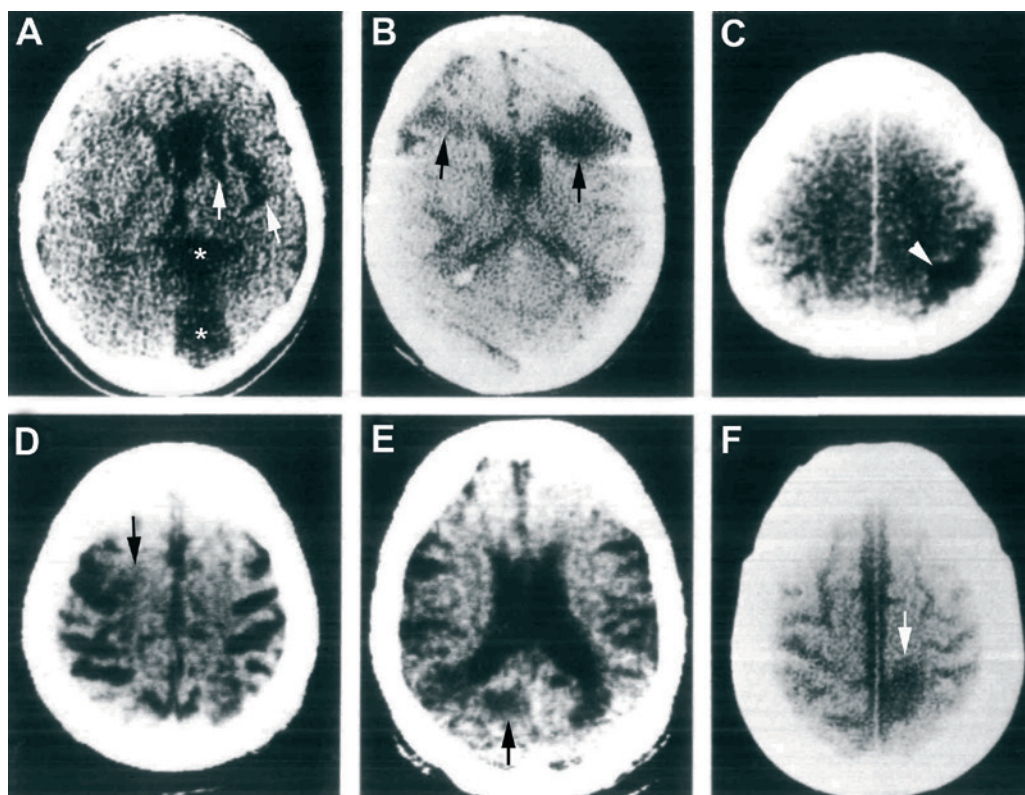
Brain CT scans showing multifocal, multi-territorial, and cortical-subcortical infarcts of small- to medium-size arteries (arrows), and one extensive infarct in the territory of the left posterior cerebral artery (asterisks). Note diffuse cerebral atrophy (D-F) and focal brain atrophy (C; arrowhead). A, case 3; B, case 5; C, case 7; D-E, case 2; and F, case 4. Taken from Rebollo et al.,⁴ with modifications.
